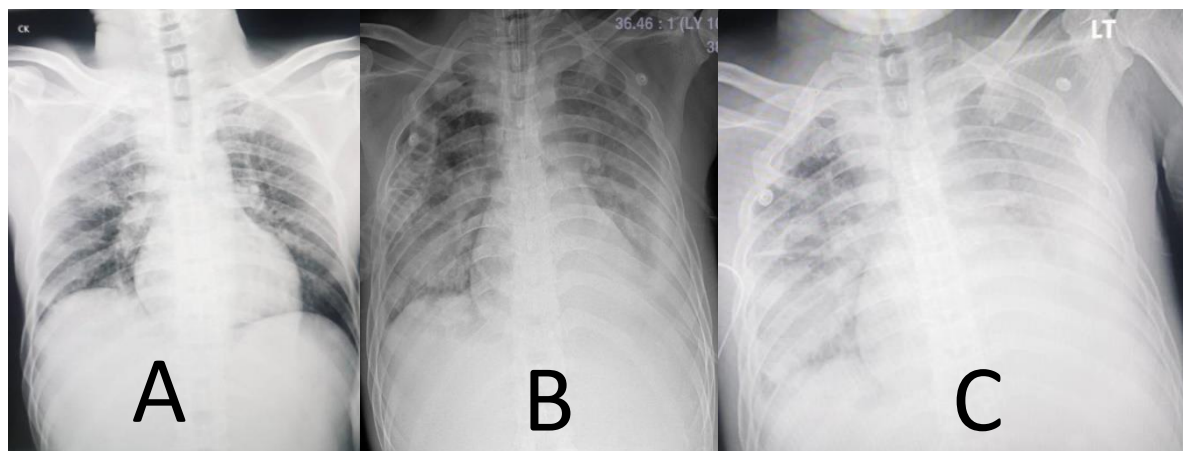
Chest x-ray (A) Day1 showed minimal patchy infiltrates at the right upper lung. (B) Day17 showed left pleural effusion and patchy infiltration at the right lung. (C) Day22 showed bilateral pleural effusion.
